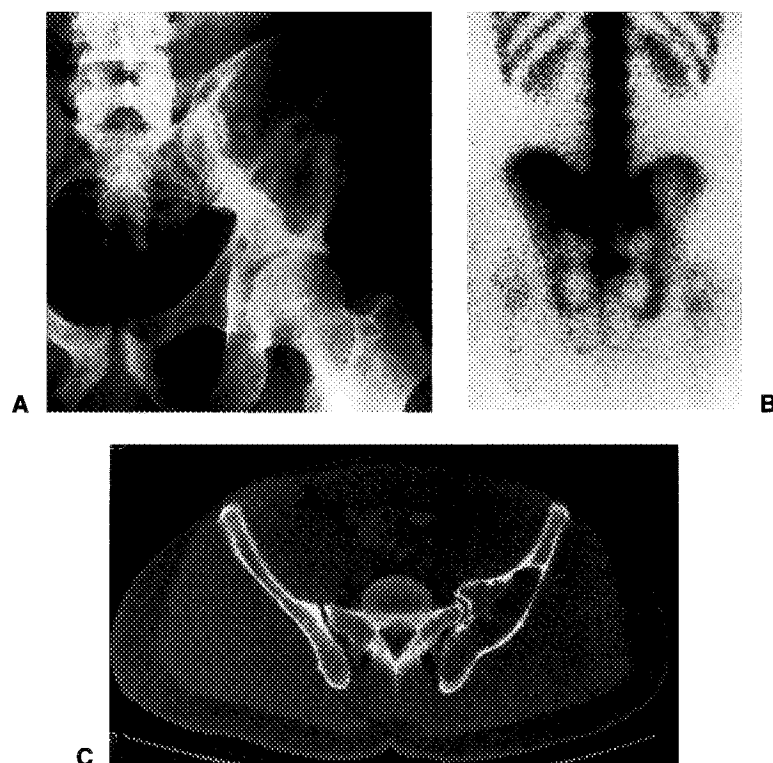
Fibrous dysplasia in a 23-year-old man. Anteroposterior pelvis radiograph (A) shows a large lesion in the left ilium. There is an expanded remodeled contour to the bone with a trabeculated appearance. No mineralized matrix is seen. Posterior delayed image from bone scintigraphy (B) shows markedly increased focal tracer accumulation in the lesion. CT (C) displayed on bone window shows the lesion to better advantage. CT identified scant mineralized matrix within the lesion (arrowhead).
